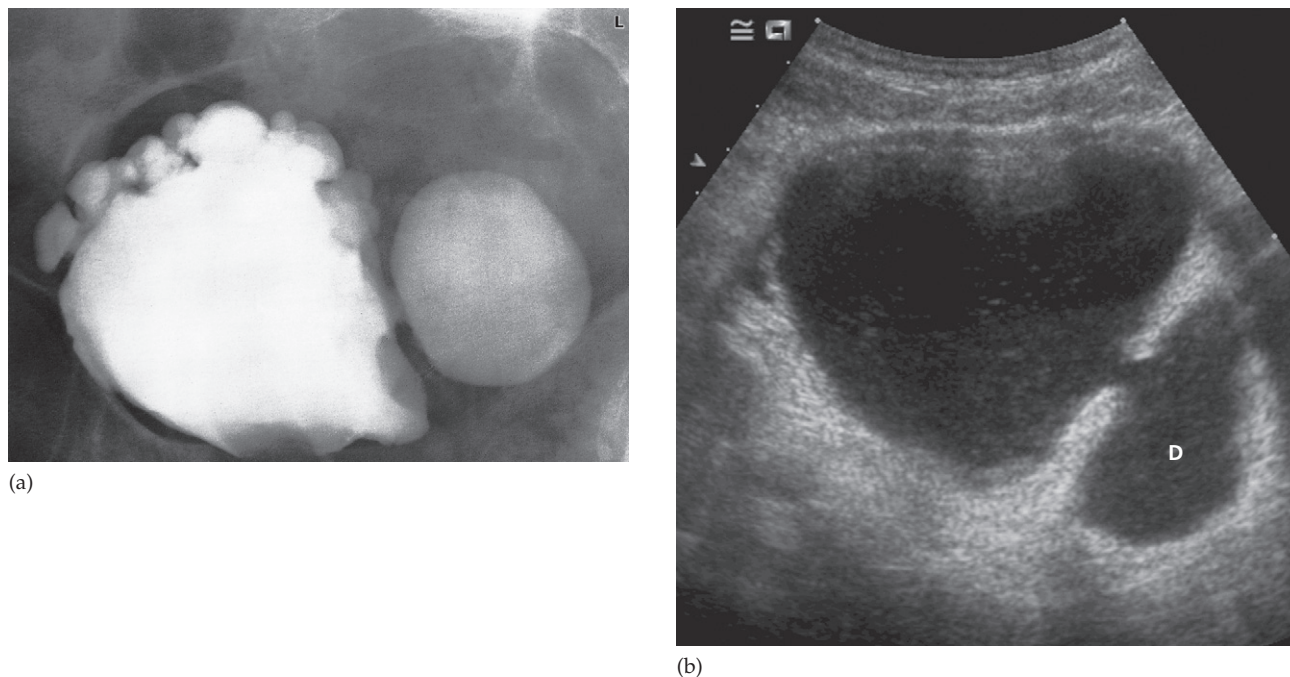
Bladder diverticula. (a) Cystogram showing numerous outpouchings from the bladder with a very large diverticulum projecting to the left. (b) Ultrasound of a large diverticulum (D) in a different patient.
